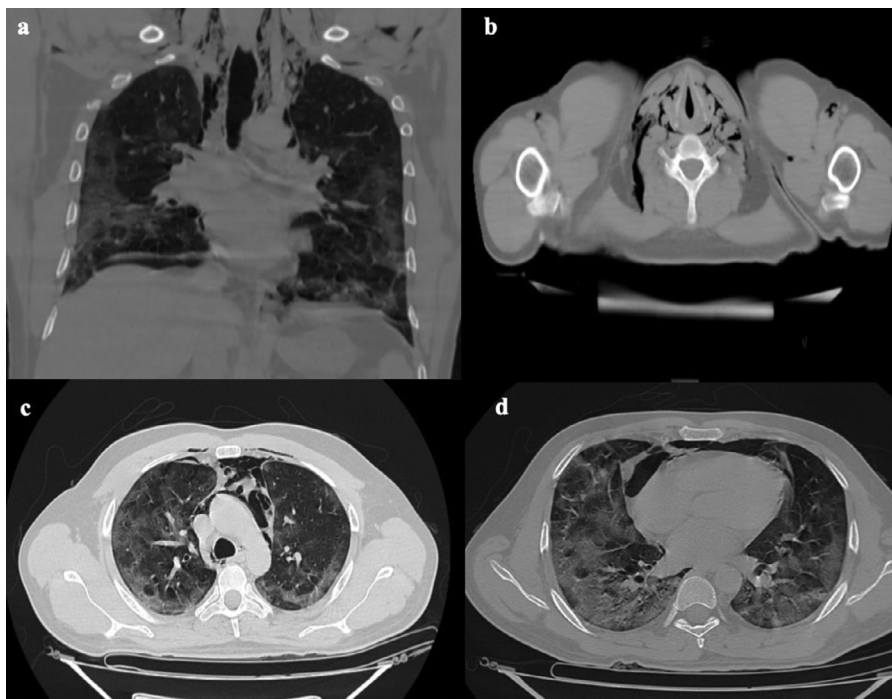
Patient Three coronal CT scan of the chest (a) and axial CT of the neck at the level of thyroid cartilage (b) revealing soft tissue emphysema tracking superiorly within the upper chest wall and neck spaces. Axial images through the chest showing multilobar peripheral ground-glass attenuation and consolidation in both lungs associated with SPM (c and d).
